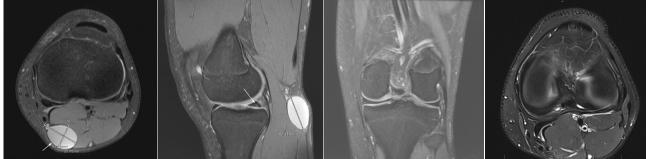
Initial Baker's cyst Figure 2. Sagittal MRI images observed on T2-weighted axial showing cyst and slight signal change in the posterior horn of the medial meniscus, MRI scan - pre-aspiration. the medial meniscus, but no discrete tear
